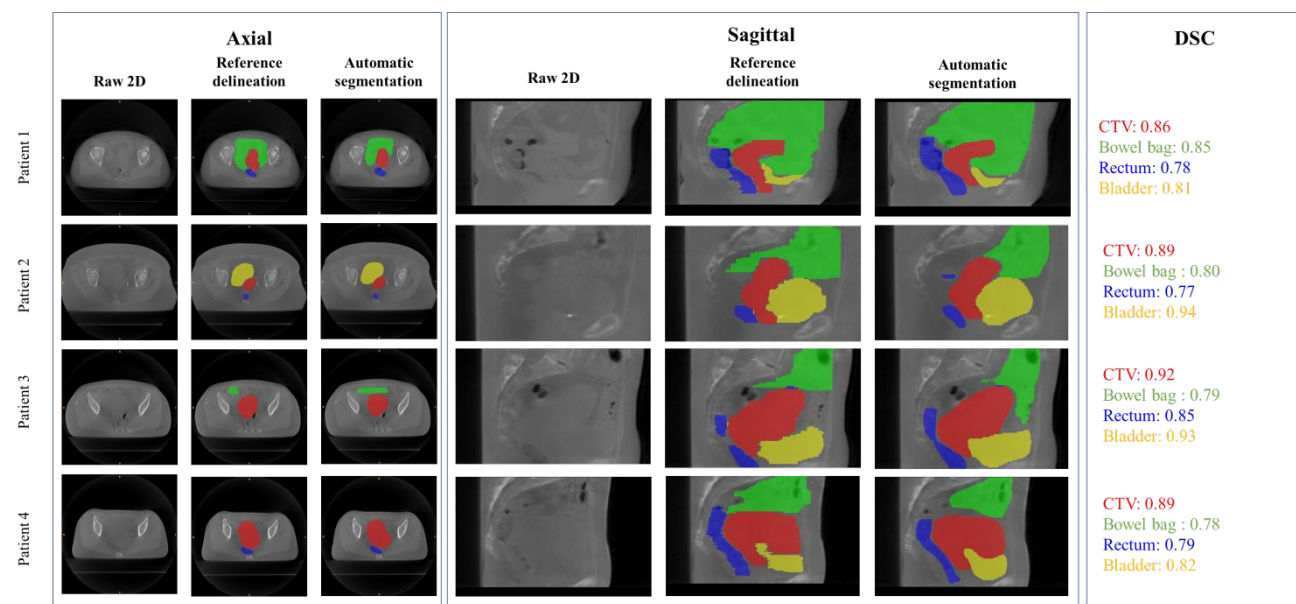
Examples of segmentation on CBCT. The contours are represented on the axial and sagittal views in red, green, yellow and blue for the primary CTV, bowel bag, bladder and rectum, respectively. DSC: Dice similarity coefficient.
